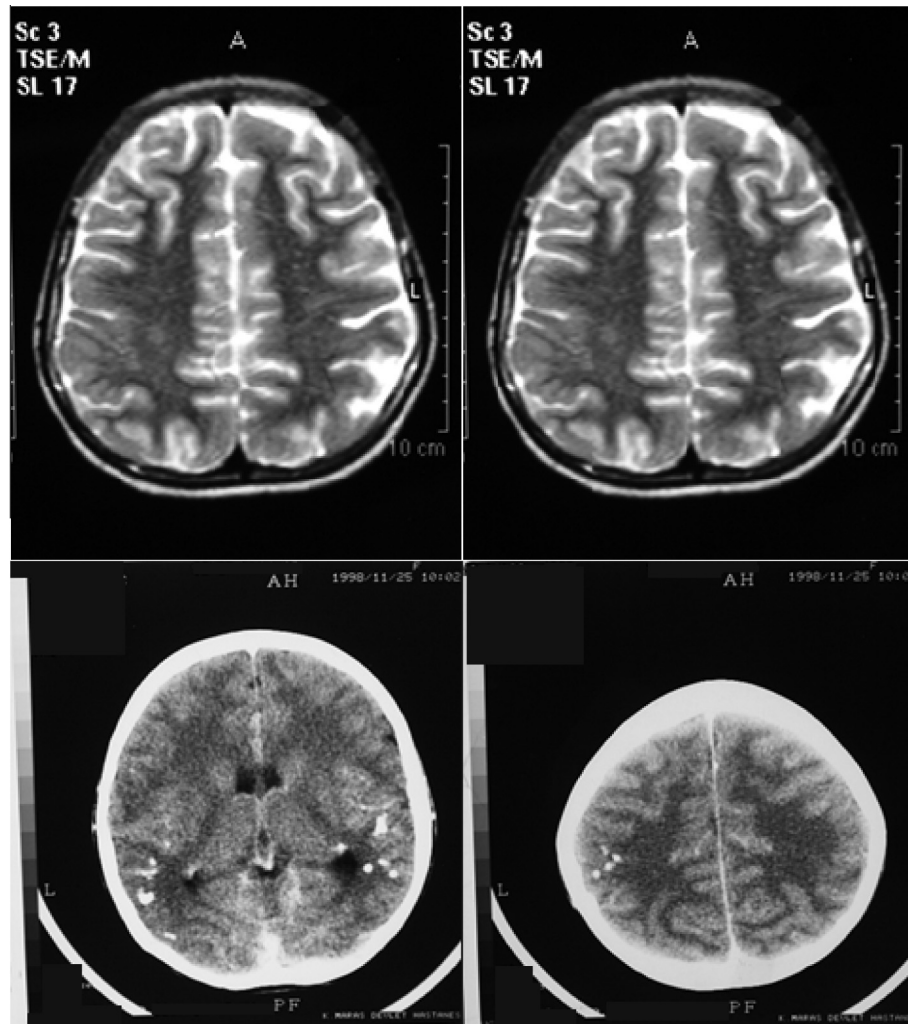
Axial T2-weighted brain MRI images of patient 19 shows right posterior frontoparietal and left parietal polymicrogyria (top), and computed tomography shows calcifications (lower) related to intrauterine CMV infection.
